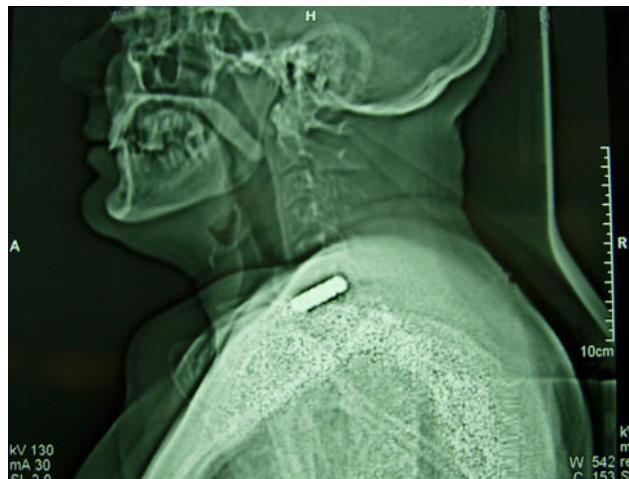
CT Scan showing bullet at level of C6
